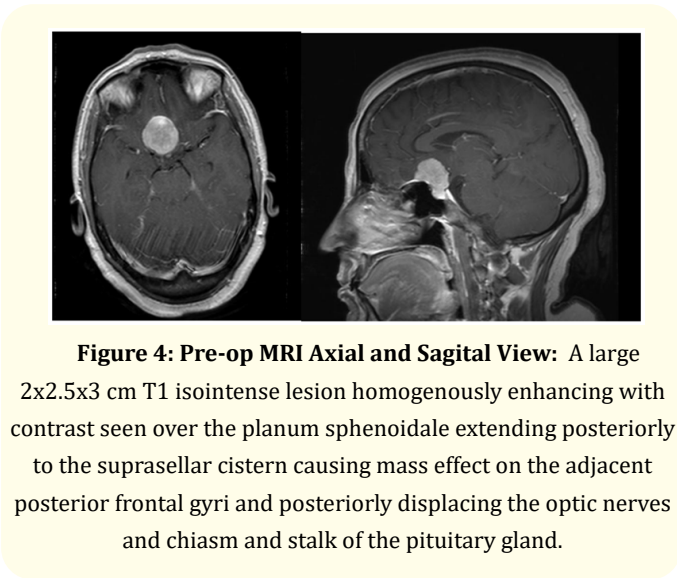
Pre-op MRI Axial and Sagittal View: A large 2x2.5x3 cm T1 isointense lesion homogenously enhancing with contrast seen over the planum sphenoidale extending posteriorly to the suprasellar cistern causing mass effect on the adjacent posterior frontal gyri and posteriorly displacing the optic nerves and chiasm and stalk of the pituitary gland.
